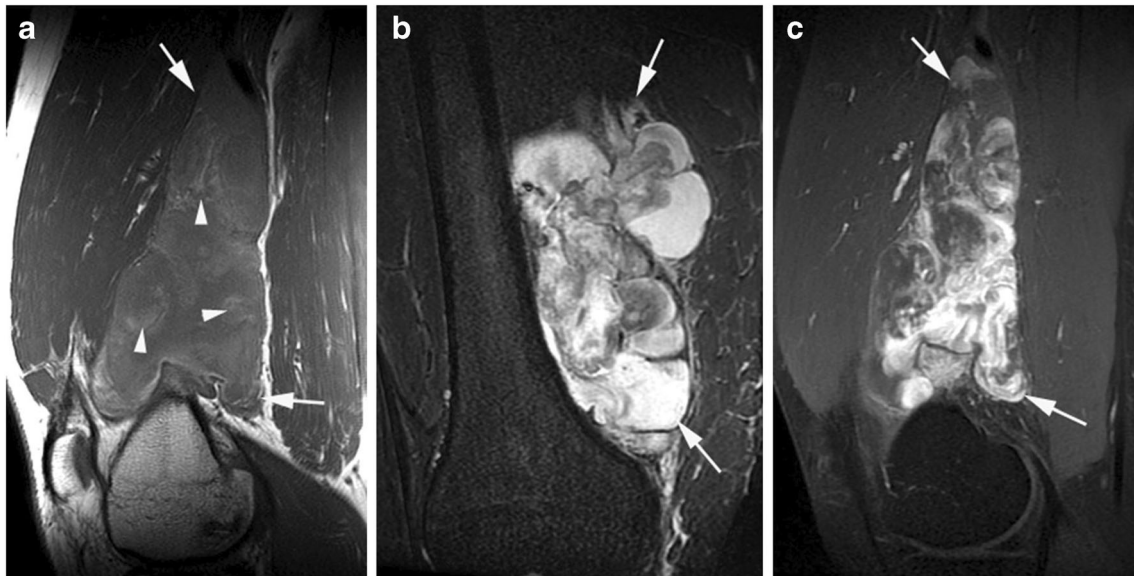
A 24-year-old male presenting with a mass in the medial aspect of the right distal thigh. a Sagittal T1W TSE, b coronal STIR, and c sagittal fat suppressed post-contrast T1W TSE MR images show a poorly defined, lobular mass (arrows) located between the femur and the vastus medialis muscle. The lesion contains multiple areas on
